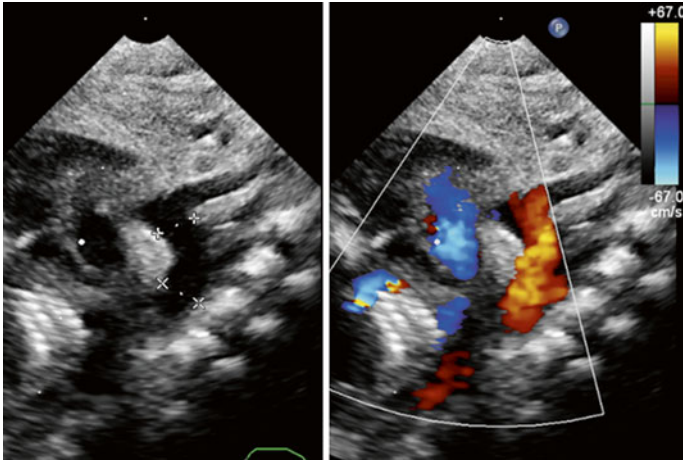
Echocardiographic suprasternal short axis shows an unobstructed aortic arch in 2-D and by color Doppler in a newborn with HLHS (MA, AA) after hybrid stage I consisting of surgical pulmonary artery banding and percutaneous duct and atrial septum stenting, respectively
